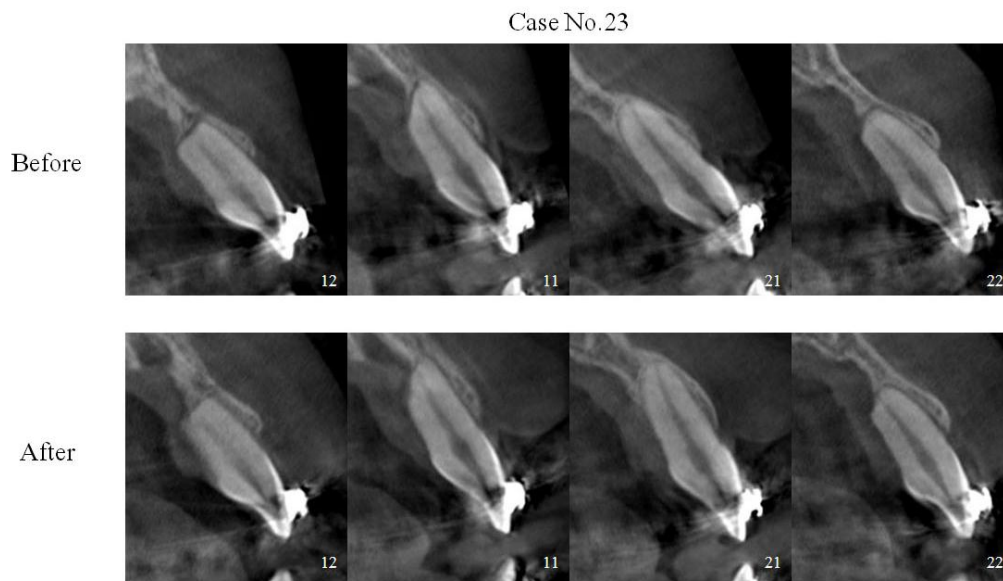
CBCT images of 23 subjects before and after incisor retraction
